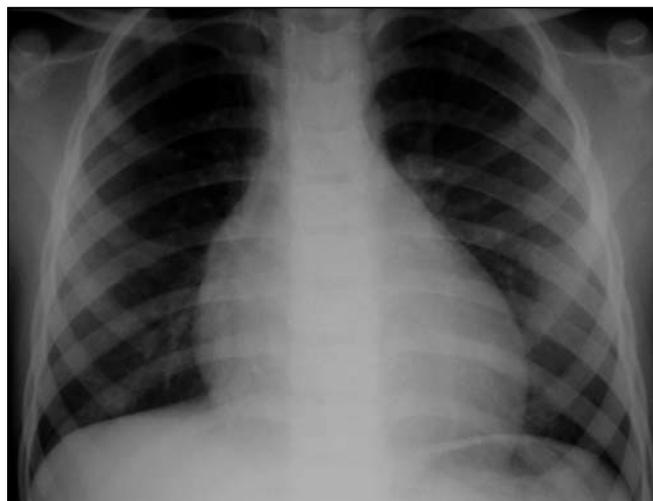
Plain radiograph of the chest demonstrating a bifid 4th rib on the left.
